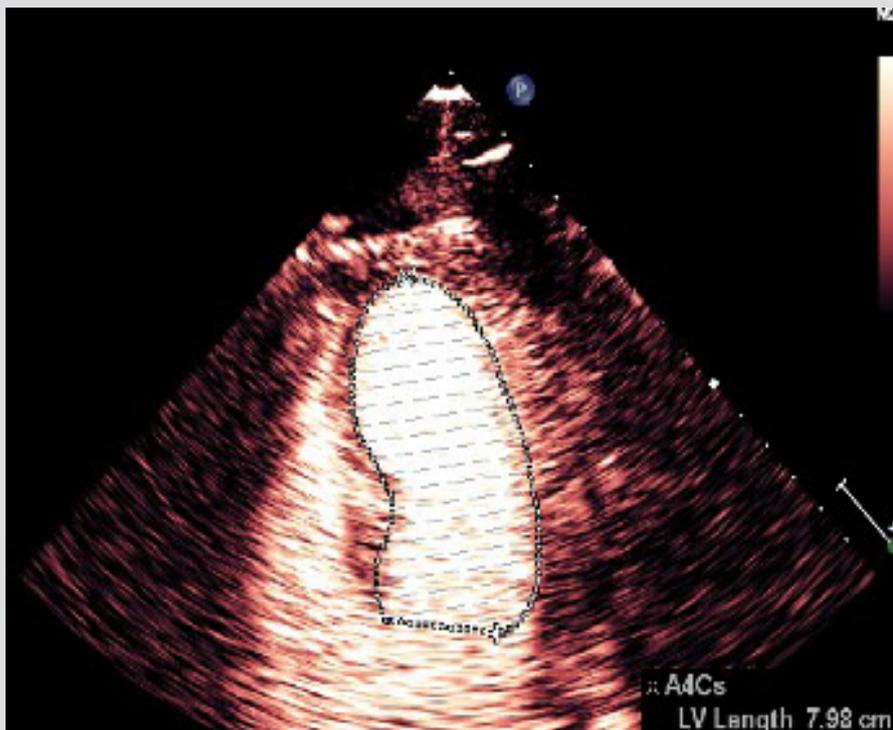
Transthoracic echocardiogram demonstrating apical ballooning of the left ventricle during systole, resembling the 'tako-tsubo' octopus trap
